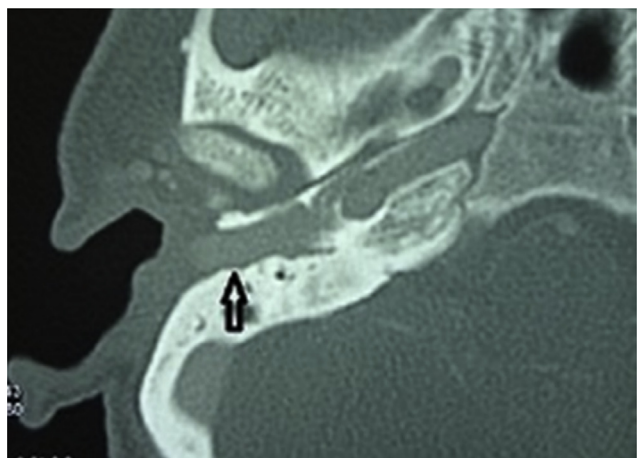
Preoperative CT of the right temporal bone demonstrating an aural polyp filling the external auditory canal (black arrow).
